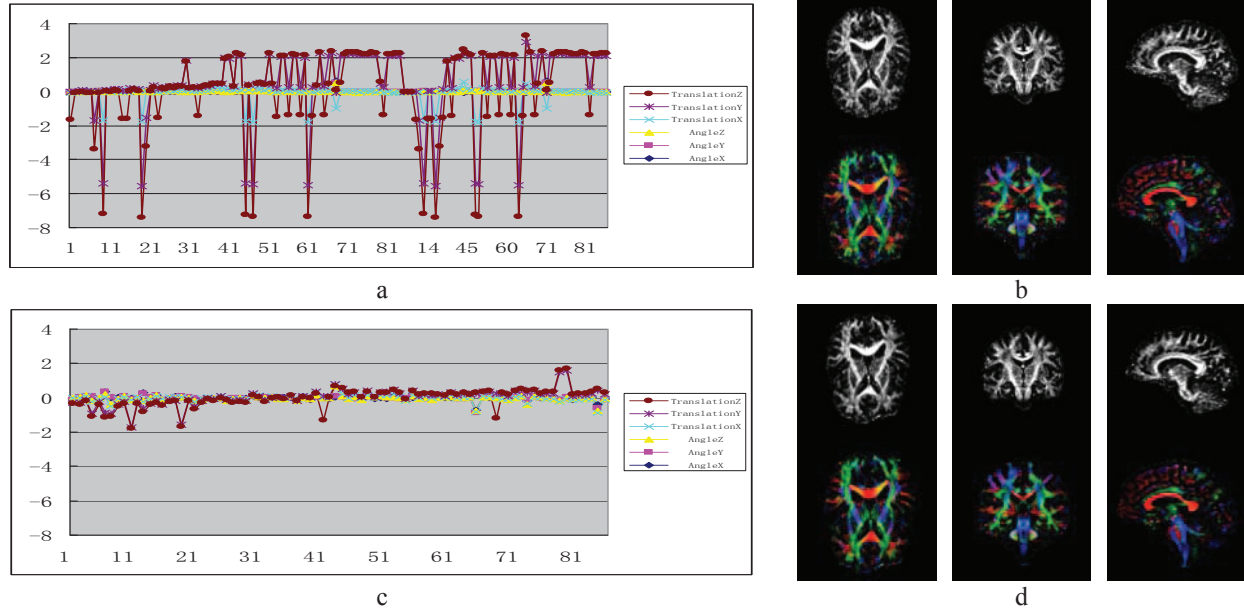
DWI quality control and artifact correction. a. Rigid registration parameters between each gradient and baseline image of the original DWI. b. FA and color coded FA images before eddy-current and motion correction. c. Rigid registration parameters between each gradient and baseline image of the corrected DWI. d. FA and color coded FA images after eddy-current and motion correction.
